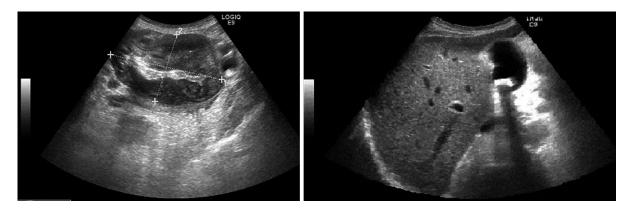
Ultrasound exam findings. The images show the concentric thickening of the wall of the ascending colon, which assumed the appearance of a solid mass. In addition the big gallstone in the lumen of the gallbladder is displayed.
